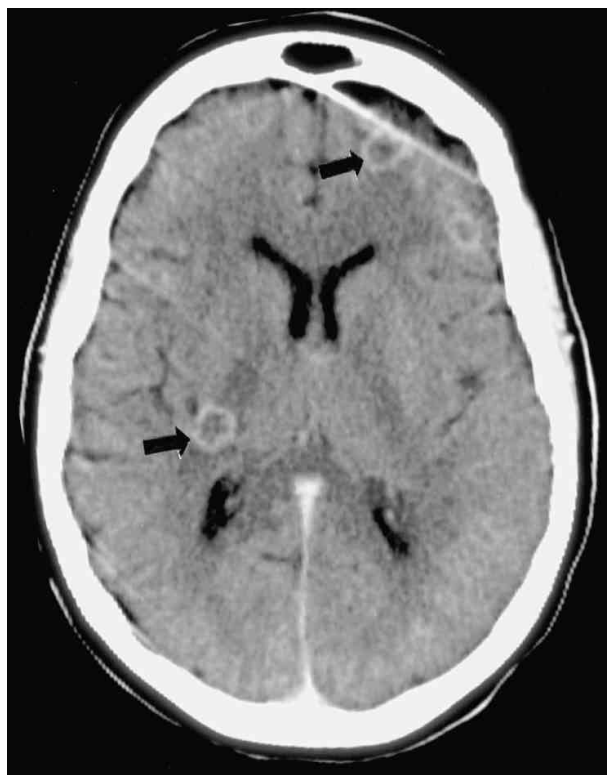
CT scan of brain showing multiple abscesses consistent with *Nocardia* metastases (arrows).
